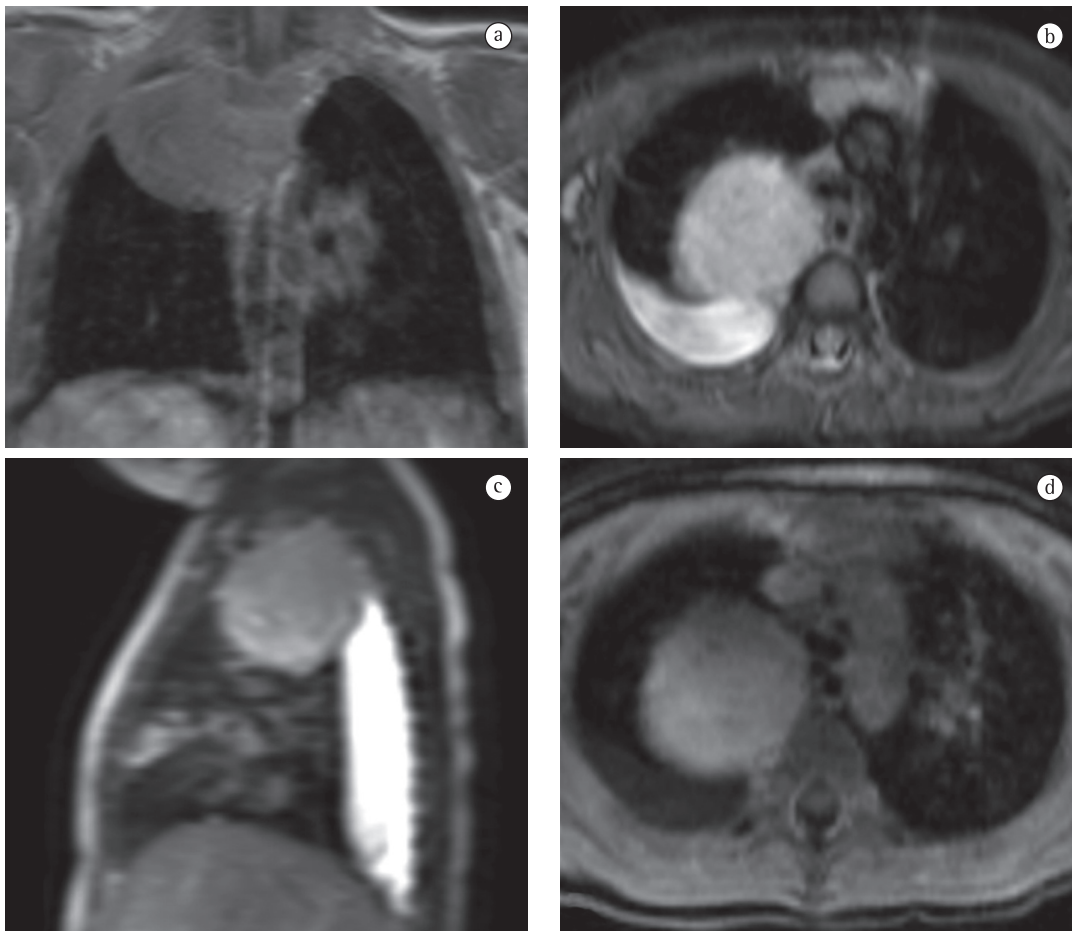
Magnetic resonance images showing ganglioneuroma. Axial T1-weighted image (a), axial T2-weighted image (b), sagittal T2-weighted image (c), and axial contrast-enhanced T1-weighted image (d) of a child with a large, round, paramediastinal mass at the apex of the right hemithorax. The lesion presents well-defined borders, homogeneously hypointense signal on T1-weighted images, hyperintense signal on T2-weighted images, and homogeneous contrast enhancement. Note also simple, homogeneous pleural effusion of moderate volume on the right.
